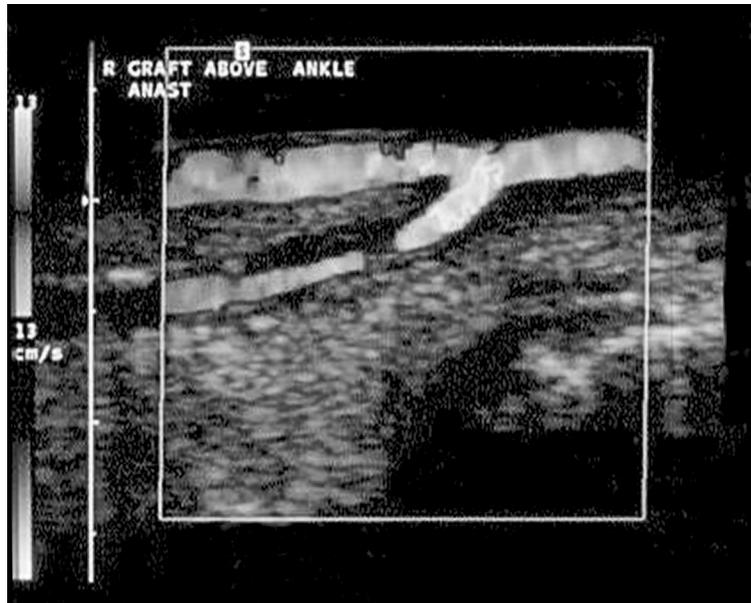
An ultrasound image of a distal graft anastomosis.
